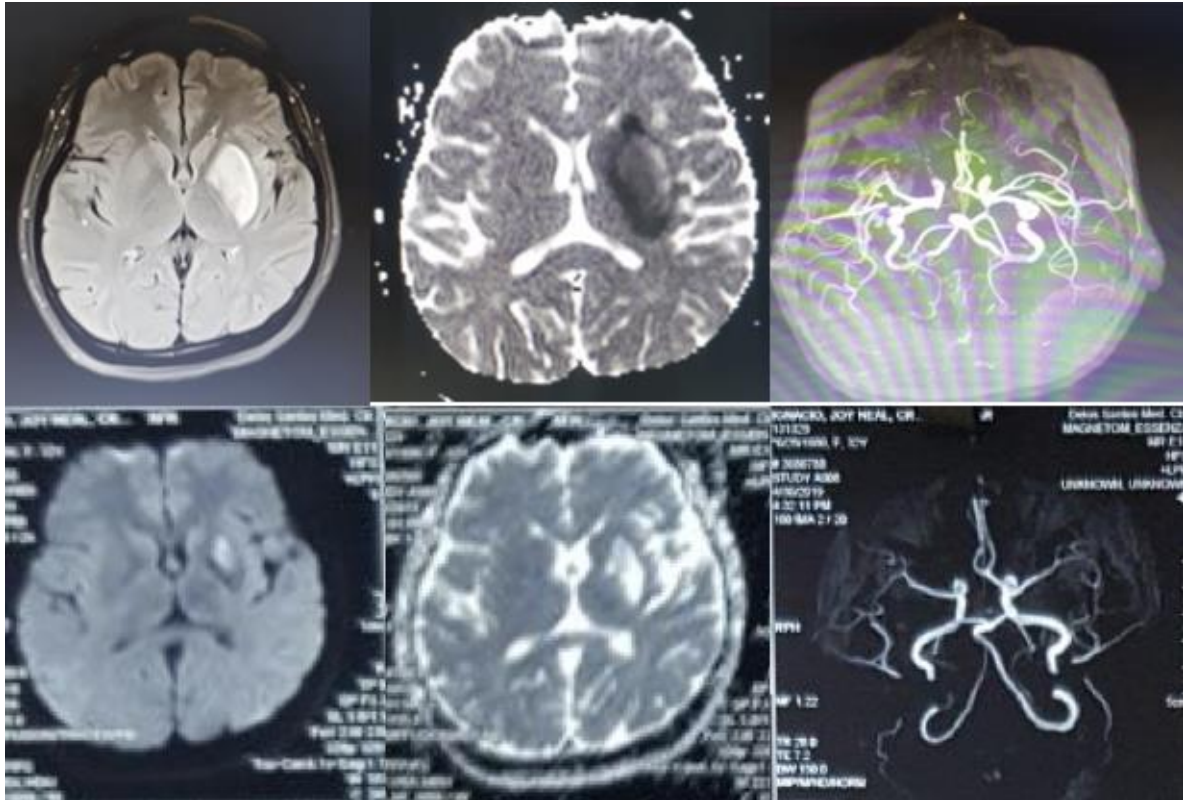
(clockwise from top-left). Upper panel: (1-month post-ictus) Restricted diffusion on the left basal ganglia on DWI. Signal drop on ADC map. Focal stenosis on the middle segment of the left middle cerebral artery. Lower panel: (3 months post-ictus) MRI no focal stenosis on MRA
